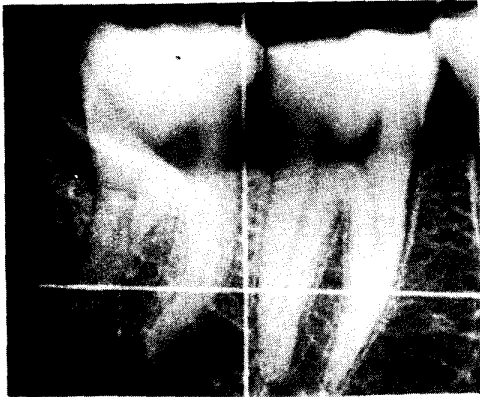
Component radiograph used for the tomosynthetic reconstruction.
